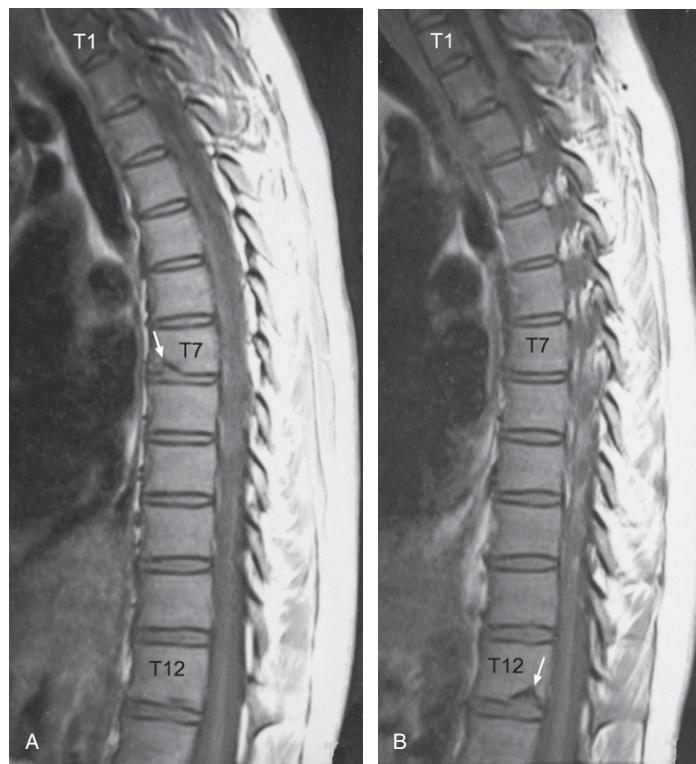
(A) Thoracic spine MRI parasagittal T1-weighted image showing a T7 vertebral body inferior endplate fracture (slice = 4.5 mm thick). (B) Thoracic spine MRI sagittal T1-weighted image showing a T12 inferior endplate fracture (Schmorl's node) (slice = 4.5 mm thick).
